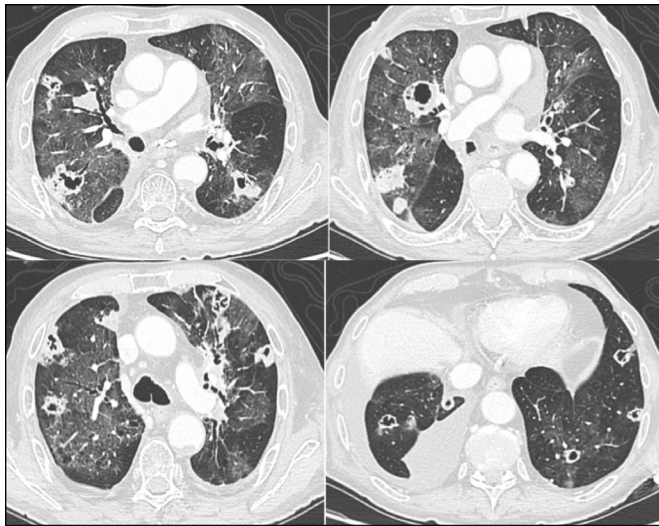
Chest CT scan with bilateral excavated nodules evoking lung abscesses, associated with diffuse bilateral ground-glass opacities.
